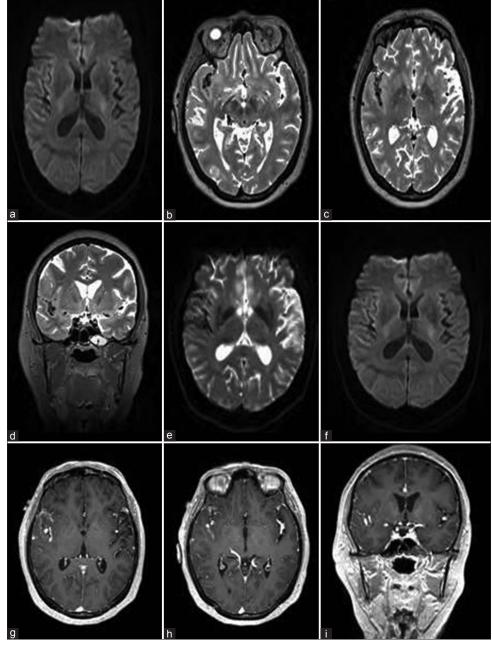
(a-i) Multiple MRI images, TI and T2, confirming multiple fusiform aneurysm dilatations involving the anterior circulation. Of interest, there is no evidence of ischemic injury on the diffusion-weighted imaging
